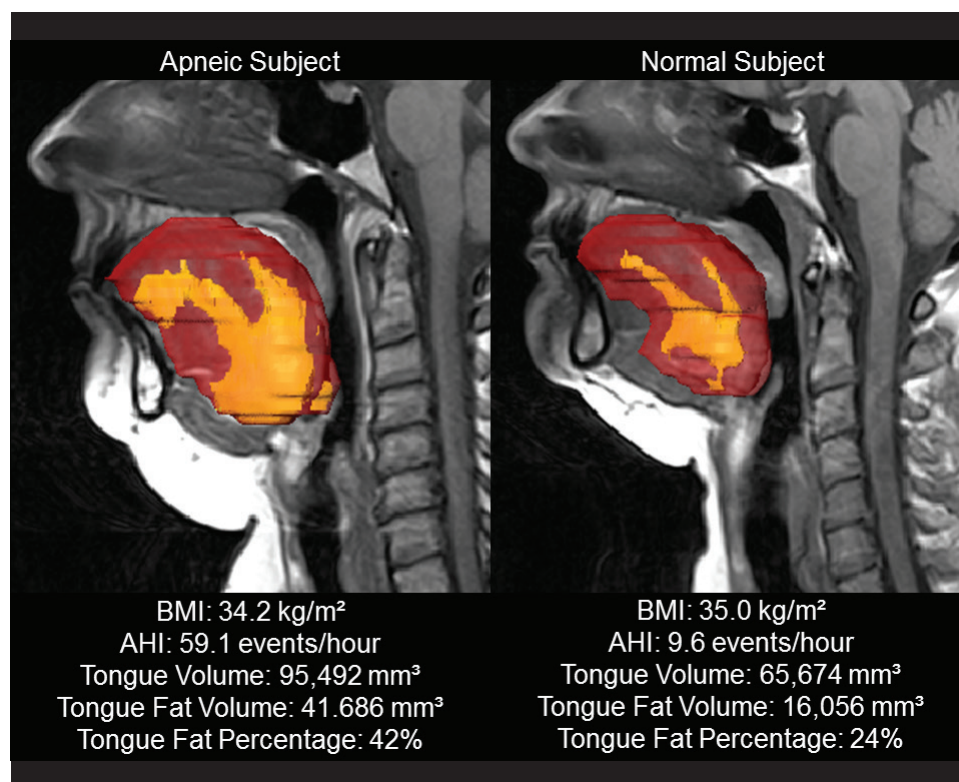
Representative three-dimensional volumetric reconstructions of tongue (red) and fat within tongue (yellow) from series of 3-mm contiguous axial MR images superimposed on midsagittal images in BMI-matched post-menopausal female patient with OSA (left) and post-menopausal female control subject (right) (subjects also matched for age and ethnicity). The apneic tongue is much larger and there is increased tongue fat deposition throughout the apneic tongue.
